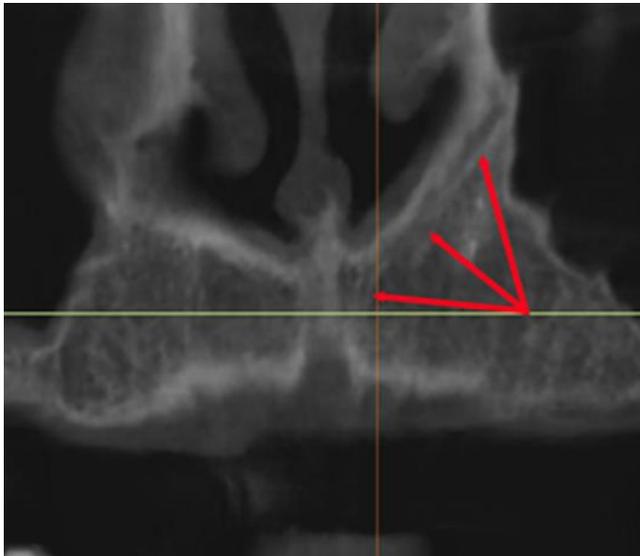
Panoramic view CBCT, CS is visualized in the lateral wall of nasal cavity, passing through maxillary alveolar crest.
